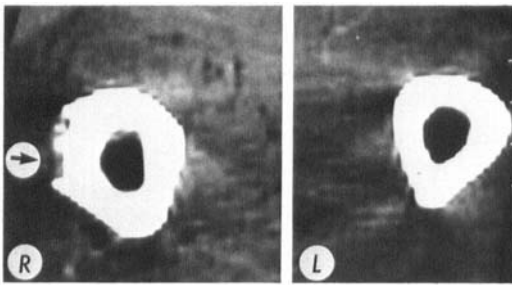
CT scan of the previously plated femur (R) and the control bone (L). The site of the plate on the lateral aspect is shown (→).
